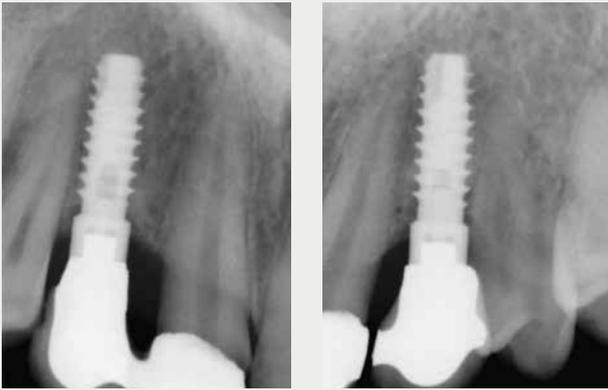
Radiographic examination showed implants 6 and 11 with stable, two-dimensional (mesiodistal) bone level.
